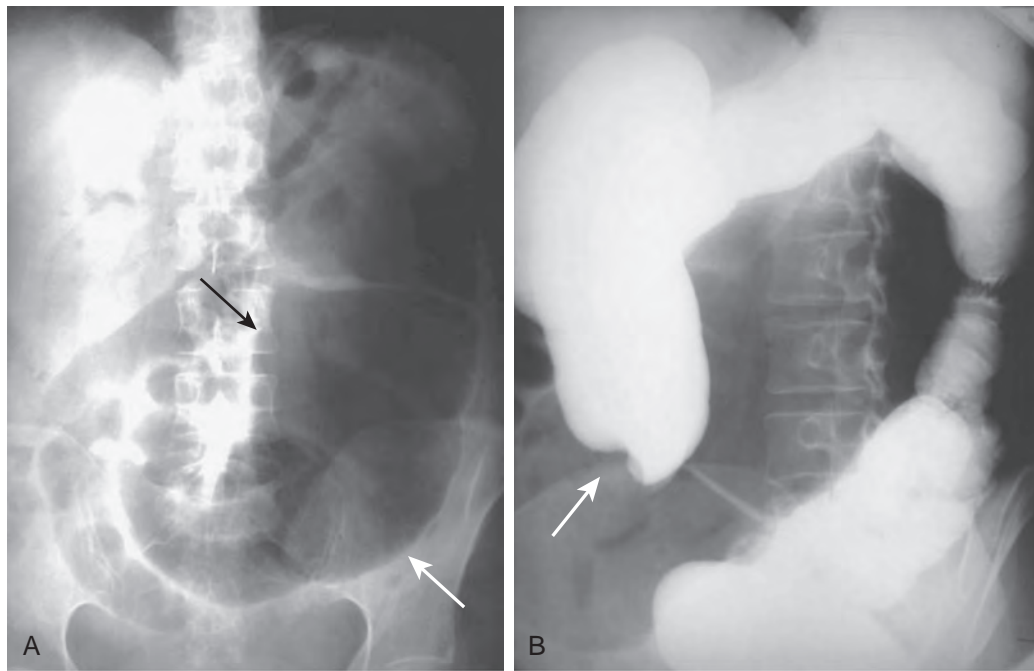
Cecal volvulus: plain radiograph and barium enema features. A. A distended cecum (arrows) is present in the left lower quadrant. Dilated small bowel is evident proximally. There is a relative paucity of colonic gas distal to the volvulus. B. Barium enema shows the contrast column ending abruptly (arrow) at the level of the twist.
